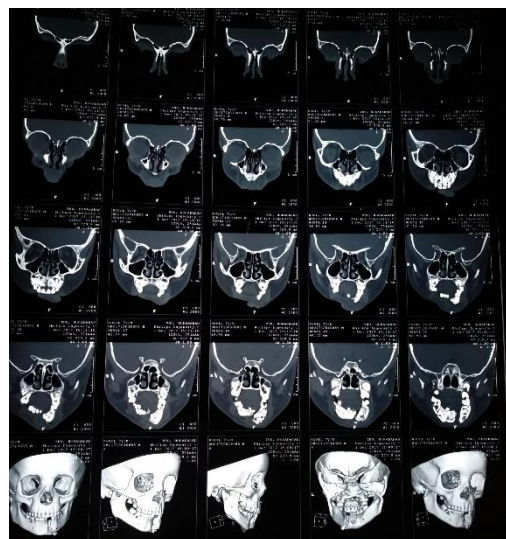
Cone Beam Computed Tomography of the Patient
